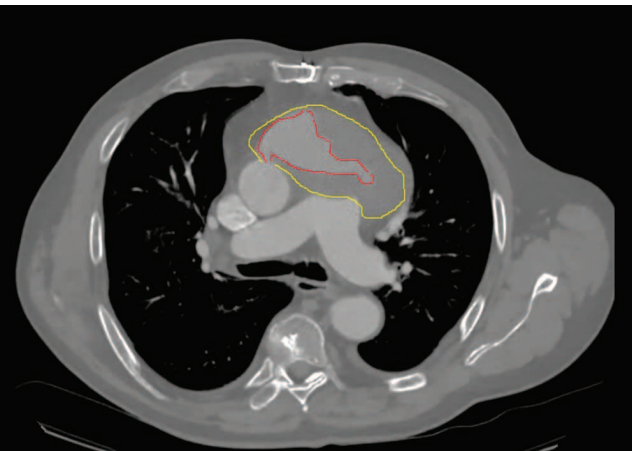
Computed tomography of the thoracic aorta with contrast, axial plane
